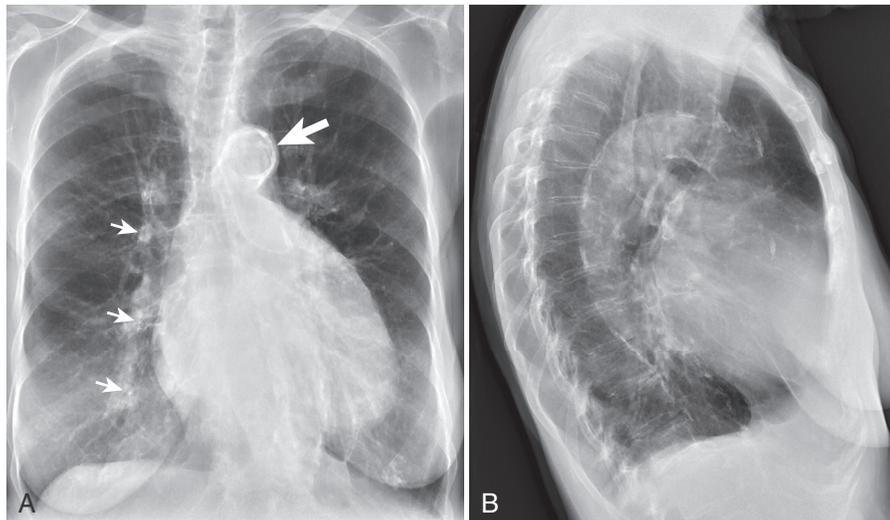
PA (A) and lateral (B) chest radiographs in a patient with aortic calcification. This is best seen on the PA view with long summation shadow-gram of aortic arch (*large arrow*). The PA view also shows calcification of tracheobronchial tree (*small arrows*), which is occasionally encountered in patients receiving warfarin. The lateral view reveals extensive calcification of aorta as well as origins of great vessels and coronary arteries.
